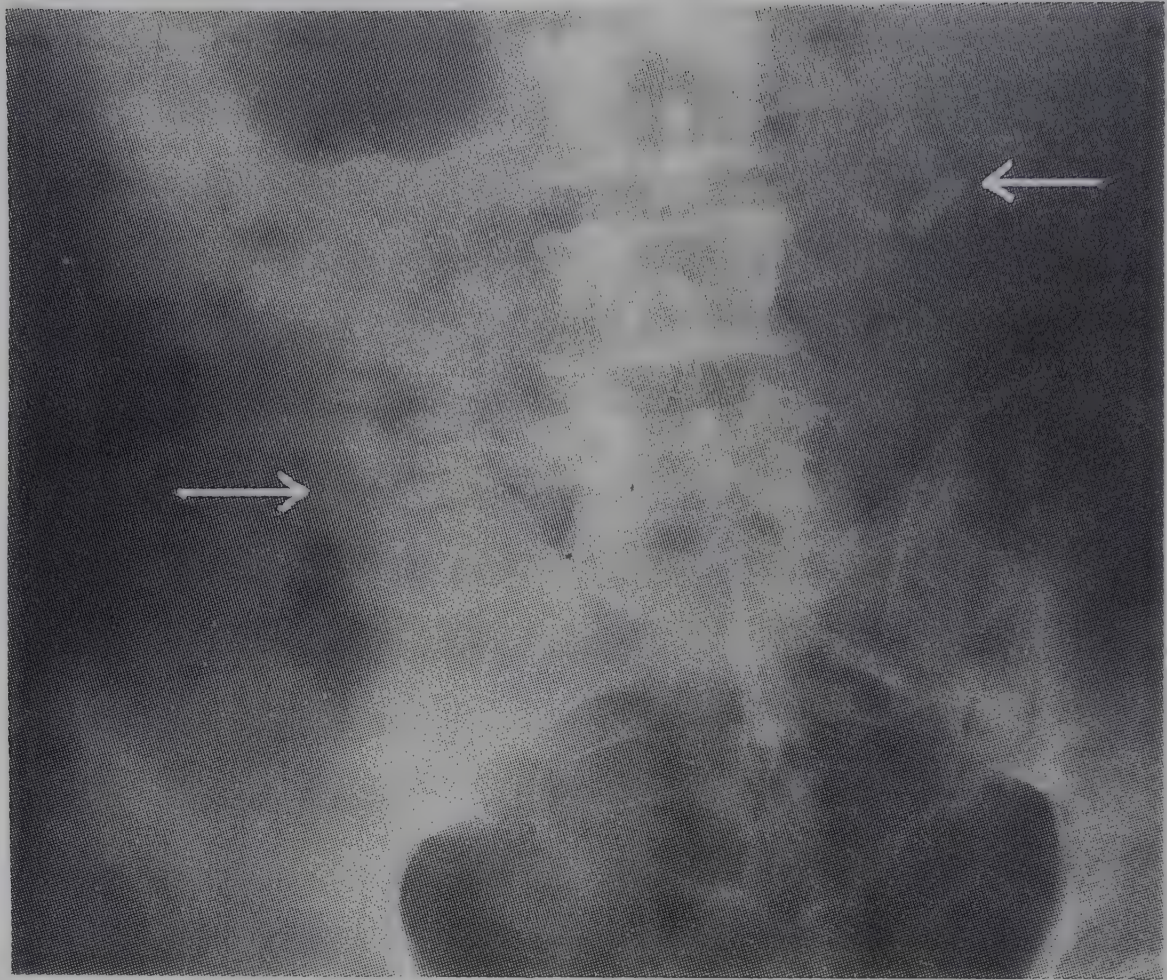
Abdominal plain x-ray showing the presence of unabsorbed hard coated tables of a drug in the colon.
